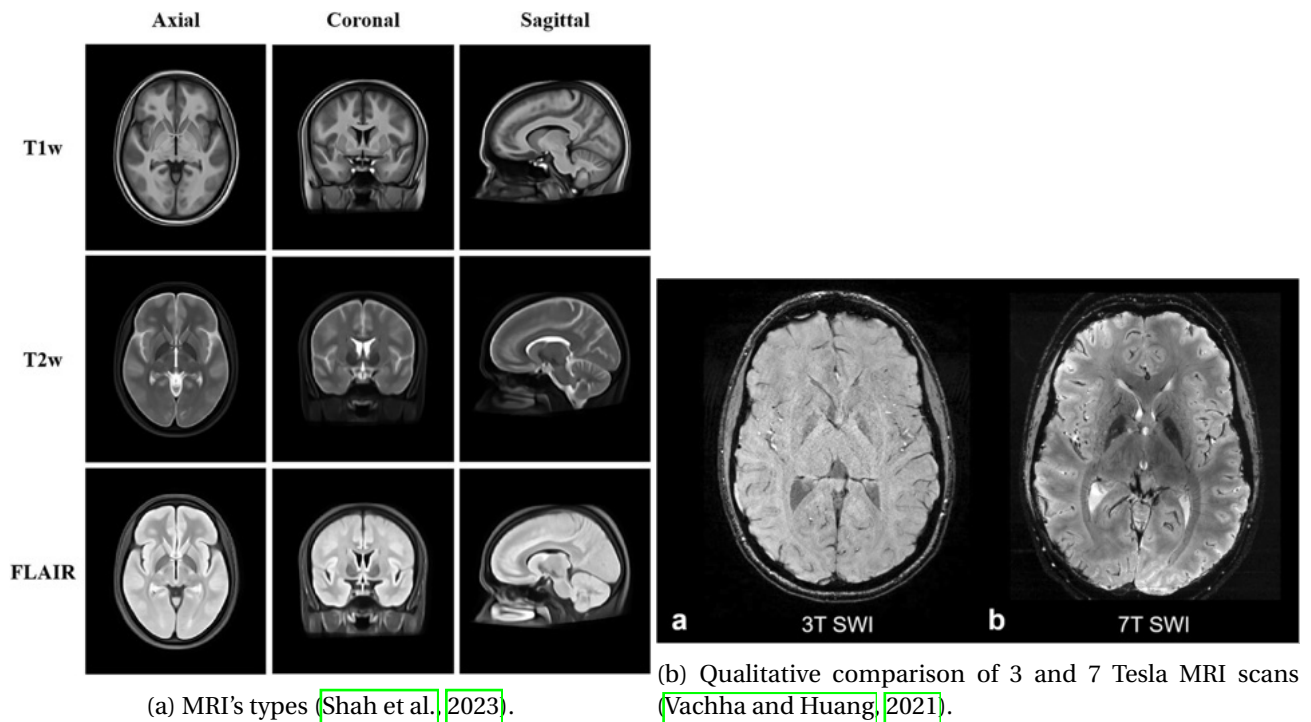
Magnetic field strength types (left) and corresponding image resolutions (right) used in brain MRI for PVS detection.
